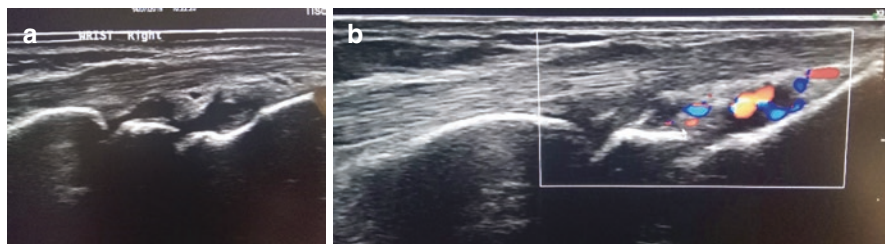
(a) Gray scale synovitis of the radiolunate and lunucapitate joints. (b) Presence of Doppler signal
